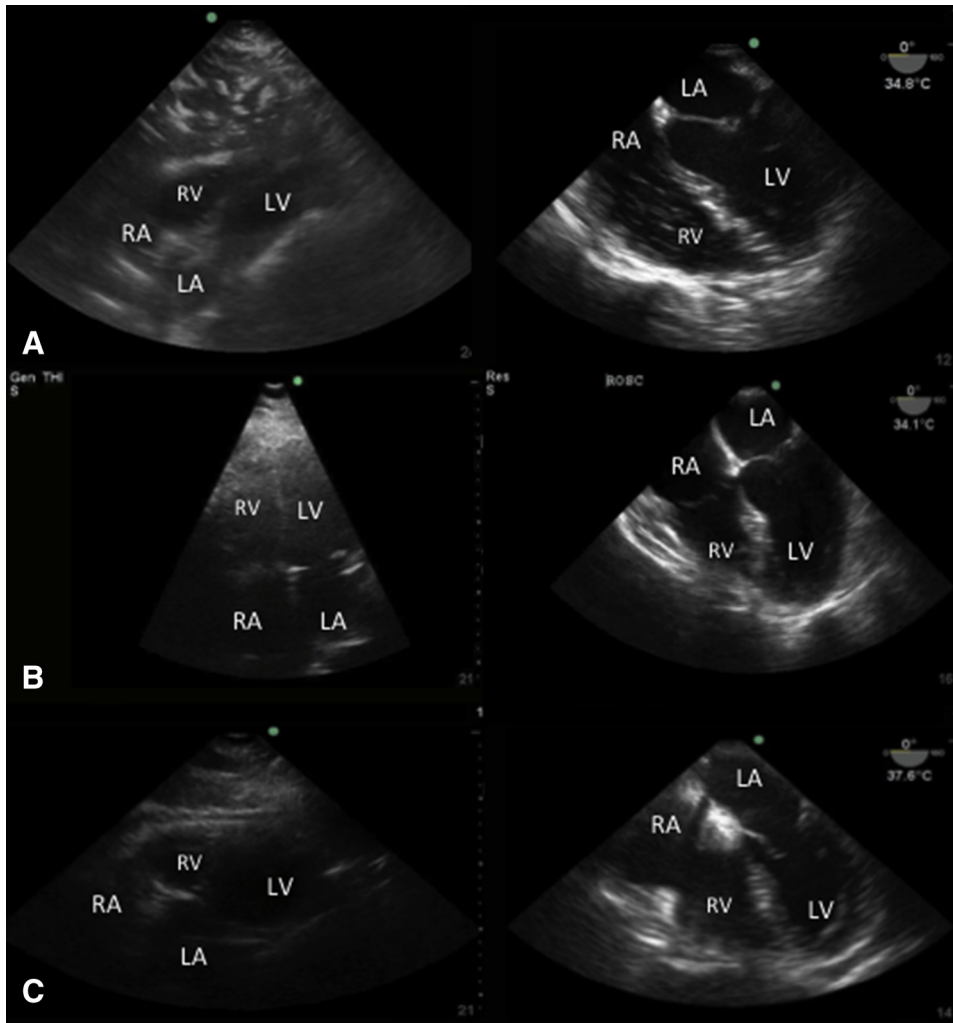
Transthoracic echocardiography (left-hand column) and transesophageal echocardiography (right-hand column) images from the same patient on the same encounter. (A) Subcostal 4-chamber view and a corresponding mid-esophageal 4-chamber view. (B) Apical 4-chamber view and corresponding mid-esophageal 4-chamber view and (C) subcostal 4-chamber view and a mid-esophageal 4-chamber view. LA = left atrium; LV = left ventricle; RA = right atrium; RV = right ventricle.
